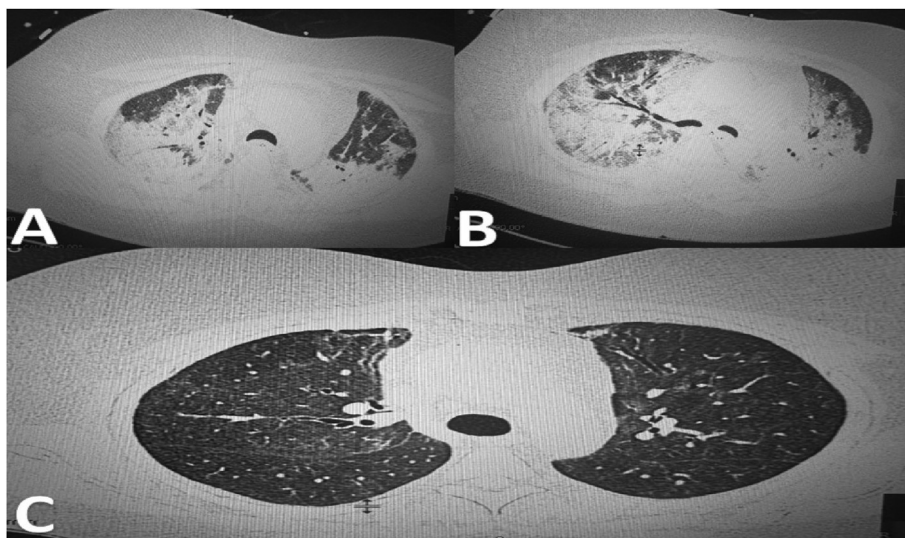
Chest CTs of 42-year-old female (Case 3). A. Admission CT shows bilateral airspace opacities with air bronchograms. B. This is a different view of the same scan sequence and shows bilateral ground glass opacities. C. CT taken three months after discharge shows improved opacities bilaterally with some ground glass opacities remaining on the right.
